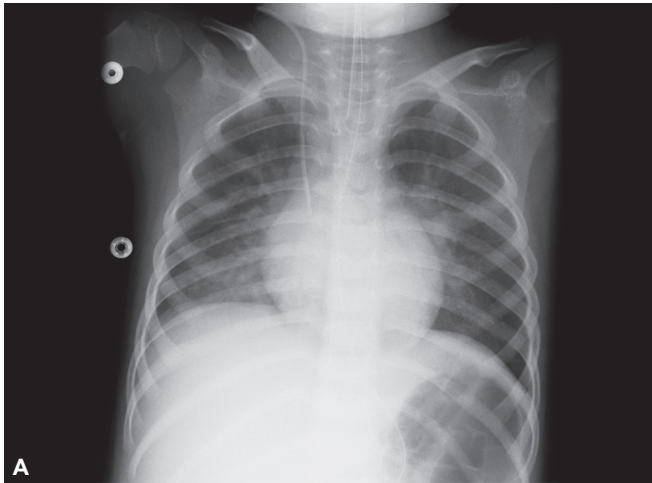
to C: Comparison between chest X-ray, chest CT and lung ultrasound in case 1.
